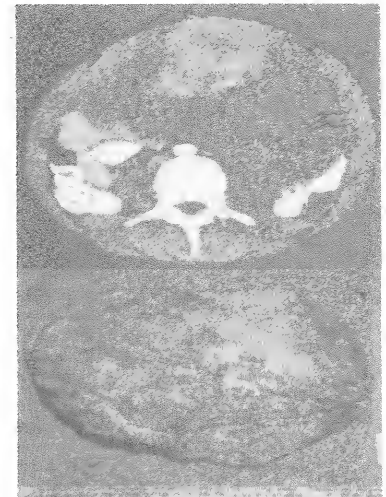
Huge desmoid tumour of anterior abdominal wall as shown on CT scan. The lower picture shows the tumour after wide excision.
